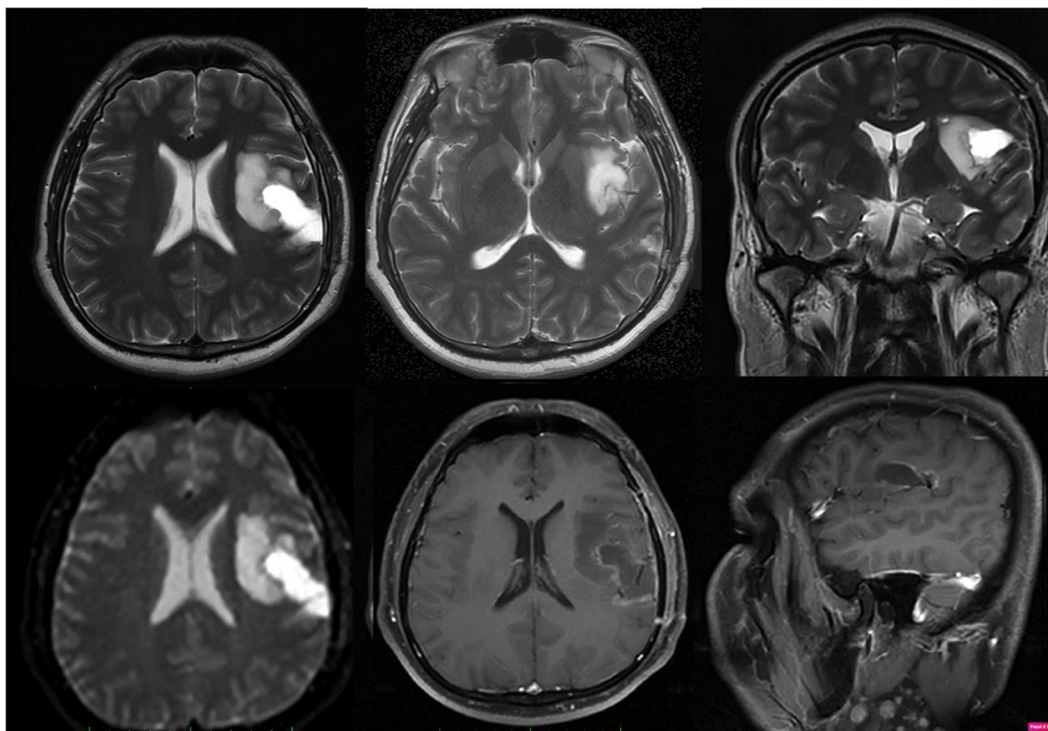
Postoperative MRI of the patient in 28 days follow-up period, depicting the partially resected apical area of the insular region, with no significant growth of the astrocytoma compared to the previous immediate postoperative brain computed tomography.
